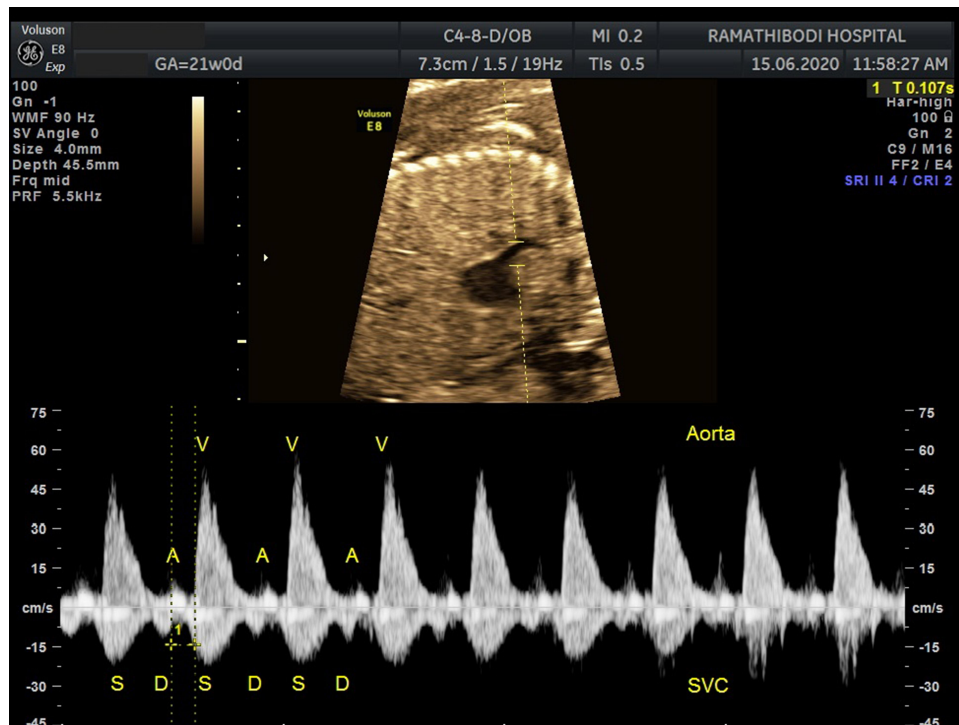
Pulsed wave Doppler image of superior vena cava-aorta (SVC-Ao) obtained from sagittal plane, time between SVC atrial wave onset and the beginning of aortic ejection flow represents mechanical PR interval.
